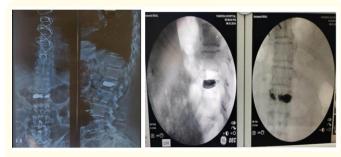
Intra op and post op x-rays showing stentoplasty in collapsed vertebrae.
